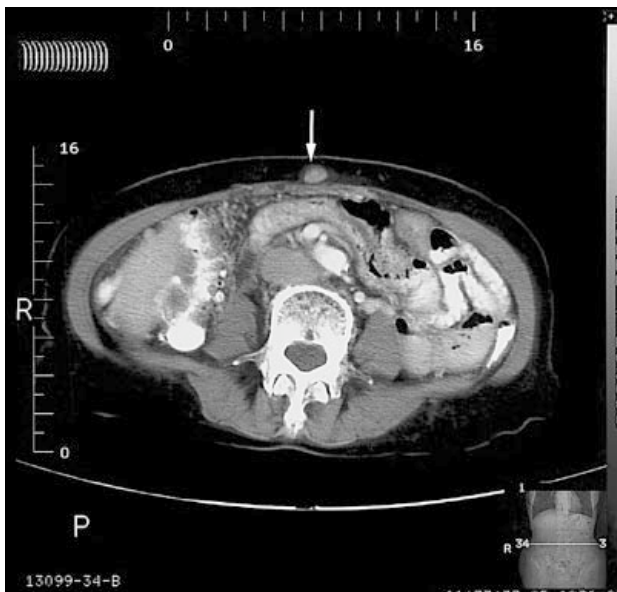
Abdominal wall metastasis secondary to a gastric stromal tumour. The patient (see Figure 2) had a gastric stromal tumour surgically excised two years before noticing a vague abdominal wall nodule just above the umbilicus. Contrast-enhanced CT abdomen confirmed a small (1 cm) subcutaneous soft tissue density nodule but no local recurrence (white arrow). The nodule was later excised and confirmed pathologically to be metastatic sarcoma.
